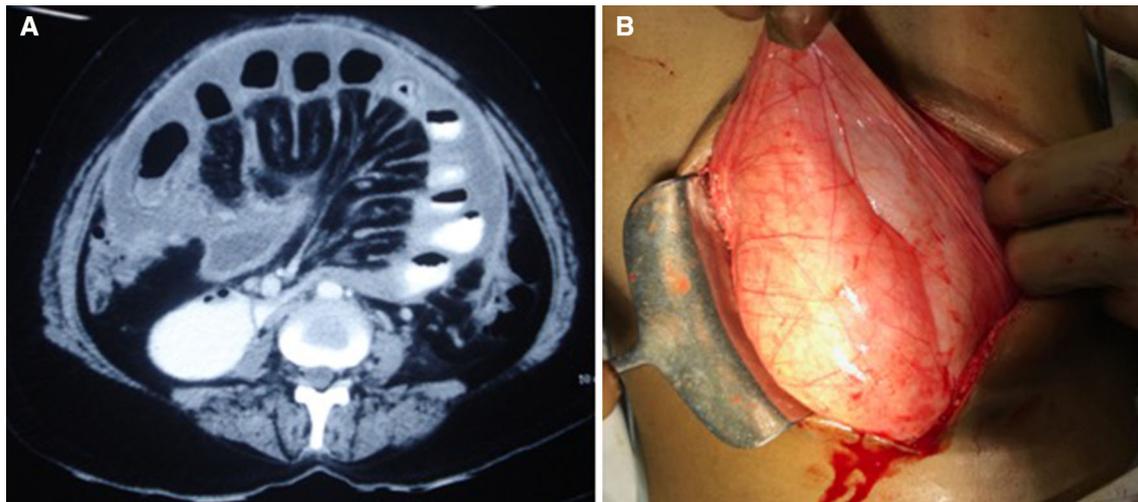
a Contrast-enhanced computed tomography showing membranes encasing the small bowel loops. b Intra-operative picture showing complete encasement of bowel loop with cocoon-like membranes
